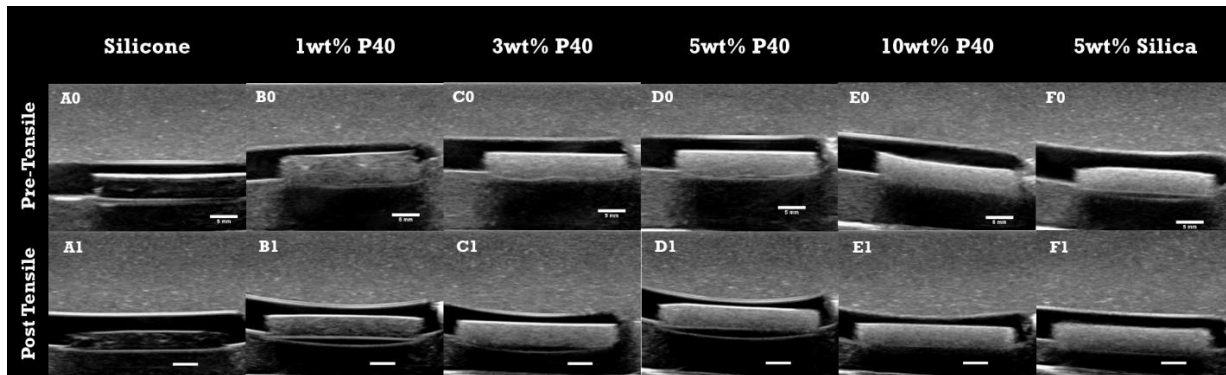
Ultrasound comparison of Pre-Tensile tested samples (A0-F0), and post-tensile tested samples (A1-F1). Gain 65% (Pre) and Gain 57% (Post).
